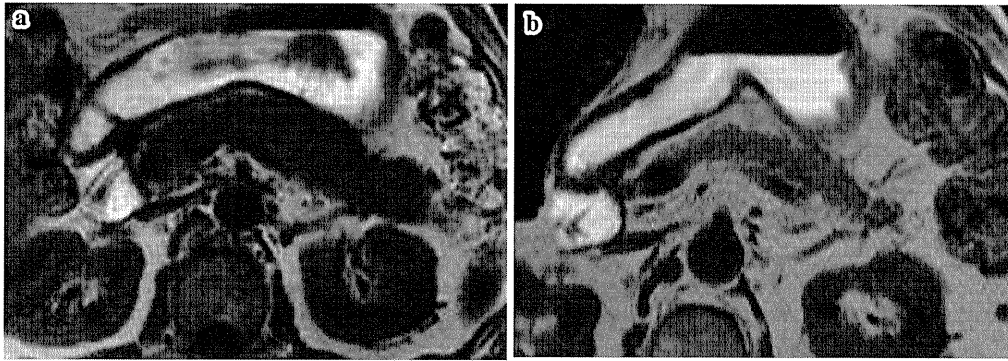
(a) Magnetic resonance imaging showing diffuse enlargement of the pancreas. (b) The pancreatic enlargement improved after steroid therapy.
